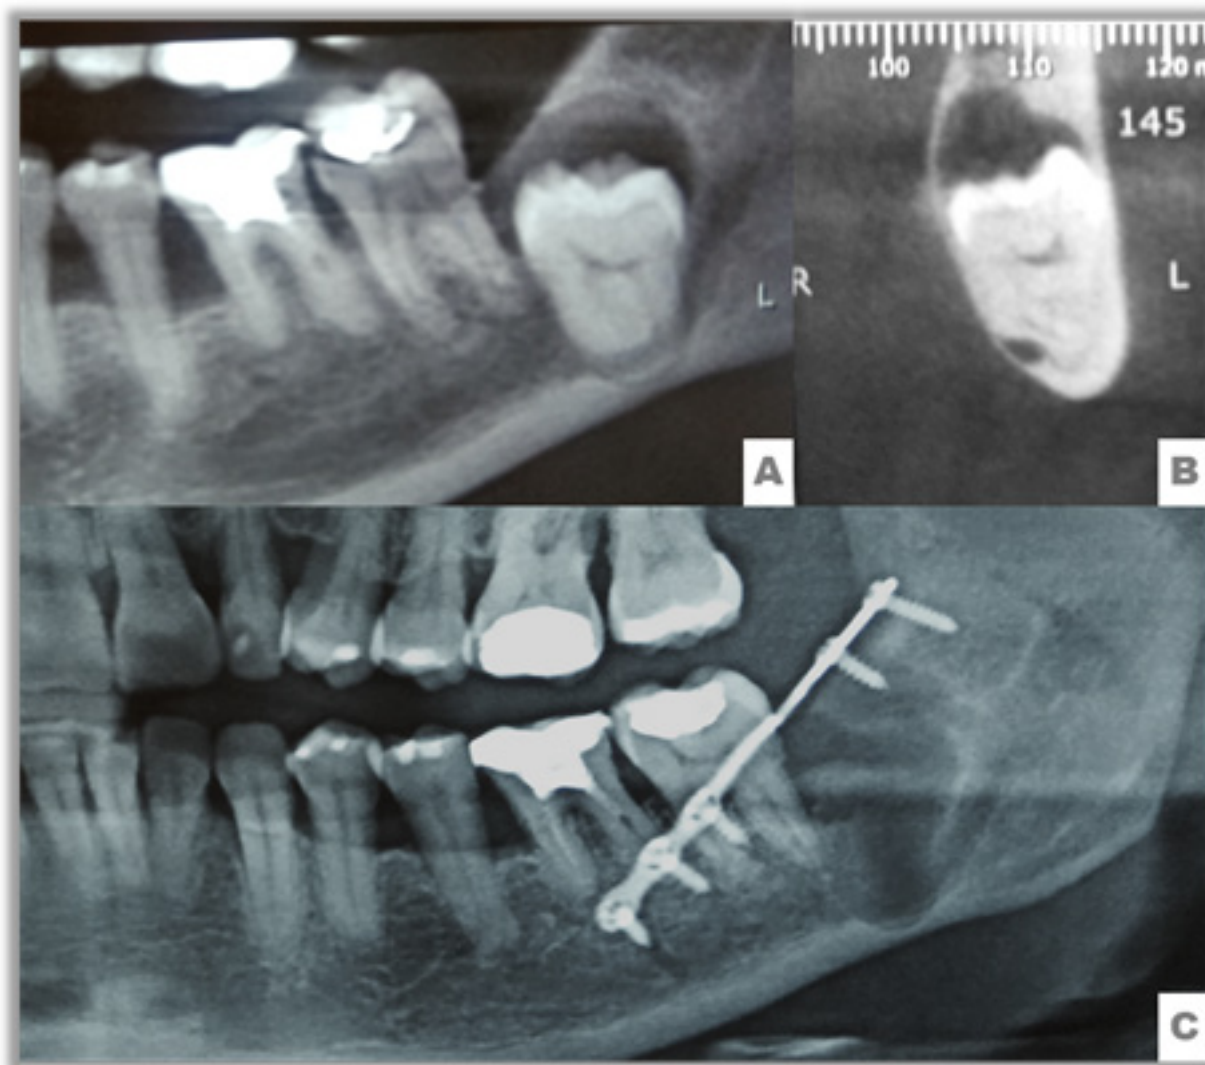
Panoramic radiography (A) and cone beam computed tomography (B) showing the retention of tooth 38 and its positioning in the region close to the mandibular angle. There is a close relationship with the inferior alveolar nerve and limited bone volume in the vestibular, lingual, and basal regions. On the panoramic radiography taken 30 days postoperatively after the tooth extraction (C), the osteosynthesis performed during the intraoperative period is demonstrated, as well as the integrity of the mandibular base.
